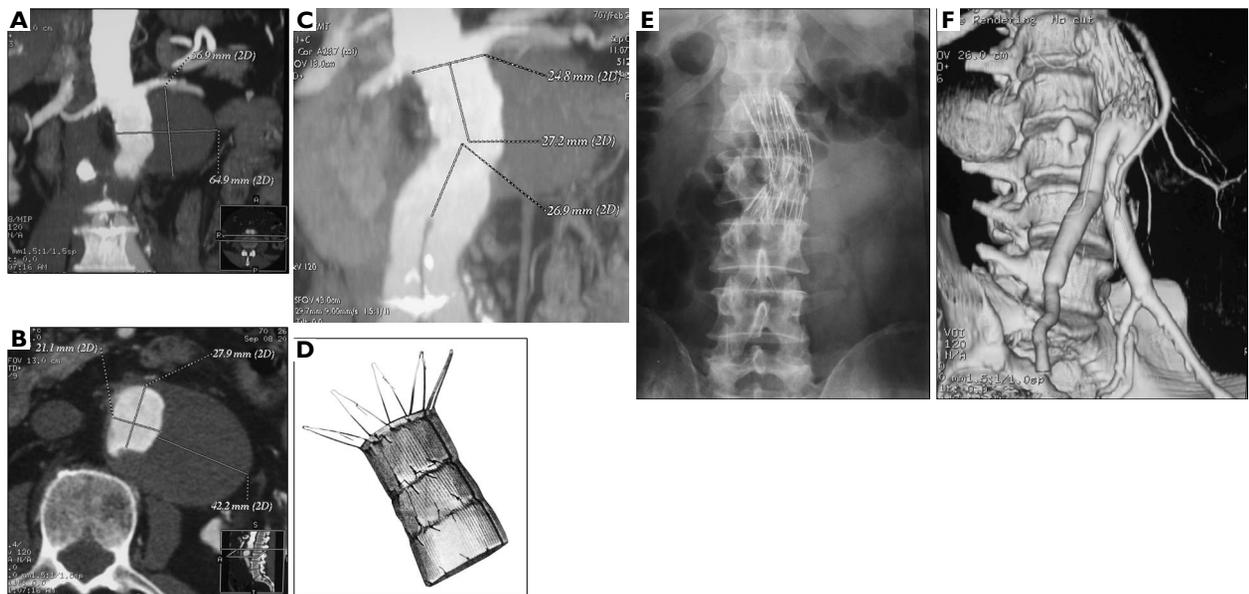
Patient 2. CT scans presenting a huge haematoma at the level of proximal anastomosis causing dislocation of the left renal artery (A, B) and 54 mm the distance between the orifices of renal arteries and bifurcation of aorto-bifemoral prosthesis (C). A custom-made tube Zenith with reduction of the diameter of each segment 28/30/32 and 56 mm in length (D). Plain abdominal X-ray showing the unique structure of the conical tube stent-graft (E). A volume rendering CT reconstruction one year after implantation shows the segmented structure of stent-graft and narrow legs of the previously implanted bifurcated prosthesis (F)
